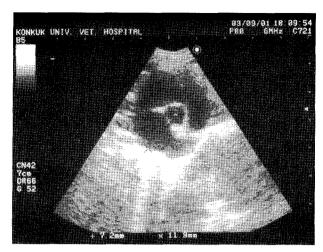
Two-dimensional echocardiography of the right parasternal short-axis view at aortic valve. The size of left atrium and left atrium (LA) to aorta (Ao) ratio were normal (11.9 mm, and LA/ Ao ratio: 11.9/7.2 = 1.65, reference range: 0.88-1.79)
